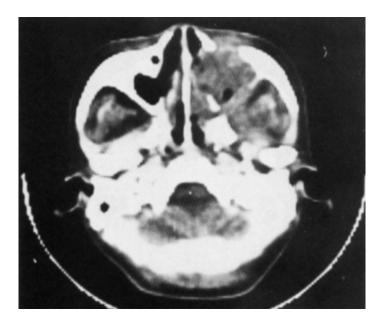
The second CT of Case 9, 10 days before the operation, after ⁶⁰Co irradiation (6000 rad (60 Gy)) showing greater bone defects of the posterior-lateral wall than the initial CT (Fig. 2A). Total maxillectomy revealed no bone defects of that wall.
